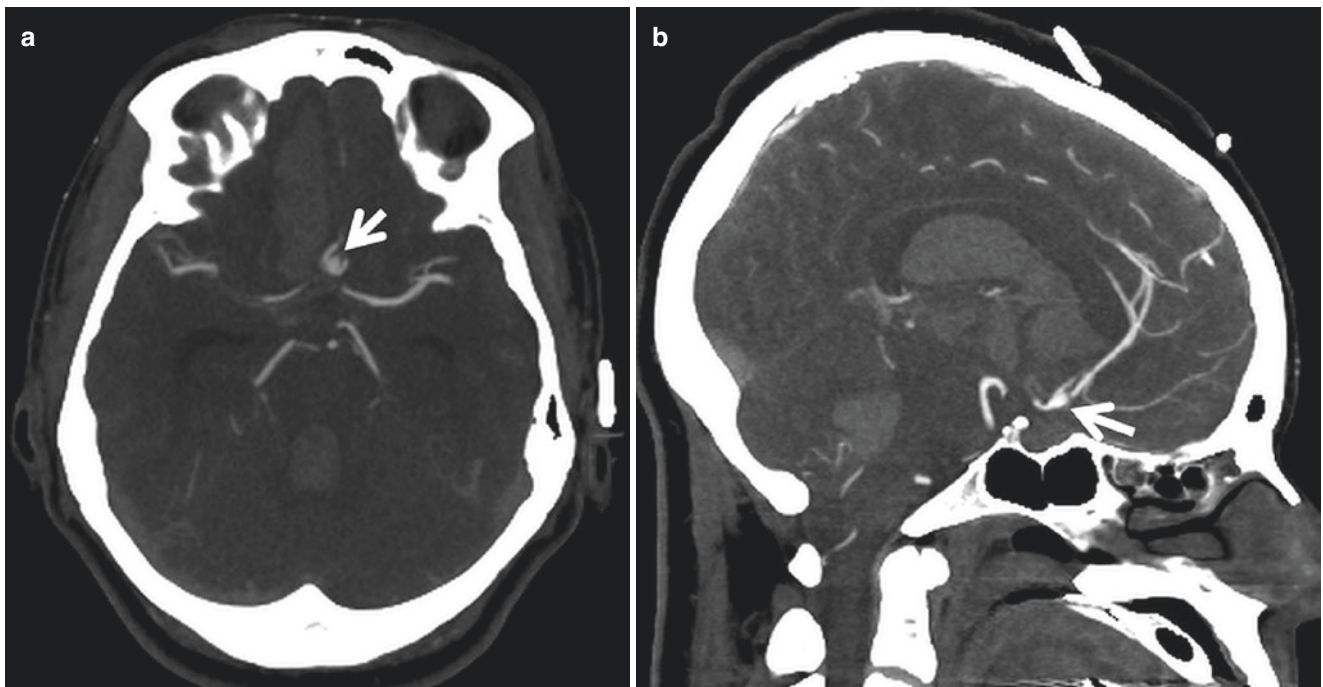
A-comm aneurysm. Patient with acute subarachnoid, intraventricular, and right frontal parenchymal hemorrhage. Axial (a) and sagittal (b) CTA shows an anteriorly projecting aneurysm (*arrow*) arising from the anterior communicating artery
